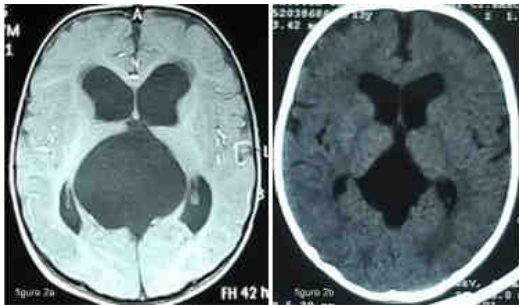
Pre-operative CT brain of 3 months male having third ventricle arachnoid cyst presented with vomiting and delayed milestones. Figure 2b - CT brain of post-endoscopic fenestration of third ventricle cyst with reduction in size seen after four weeks
